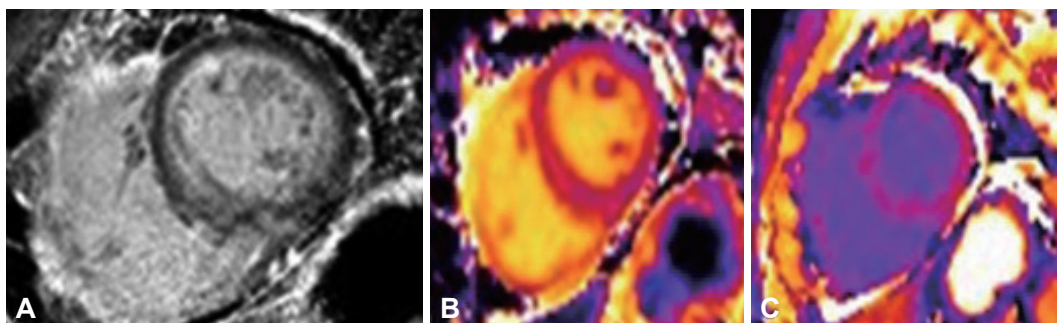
Late gadolinium enhancement (LGE) (A), pre- and post-contrast (B and C) T1 map images using 3-T MR system in a patient with secondary myocardial amyloidosis from multiple myeloma. LGE-MR image shows diffuse subendocardial gadolinium enhancement, which is a typical finding of myocardial amyloidosis deposition. Post-contrast T1 map image shows decrease of T1 value in the myocardium which enables quantification of extracellular volume fraction.
